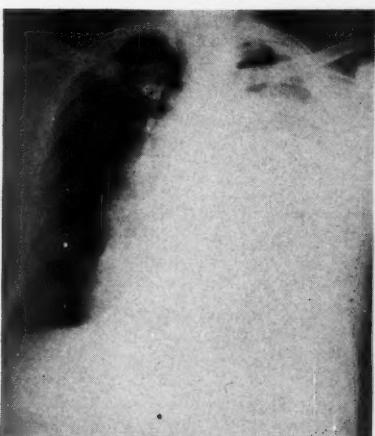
Extra pleural hemorrhage. Roentgenologist reported hemothorax on left.
